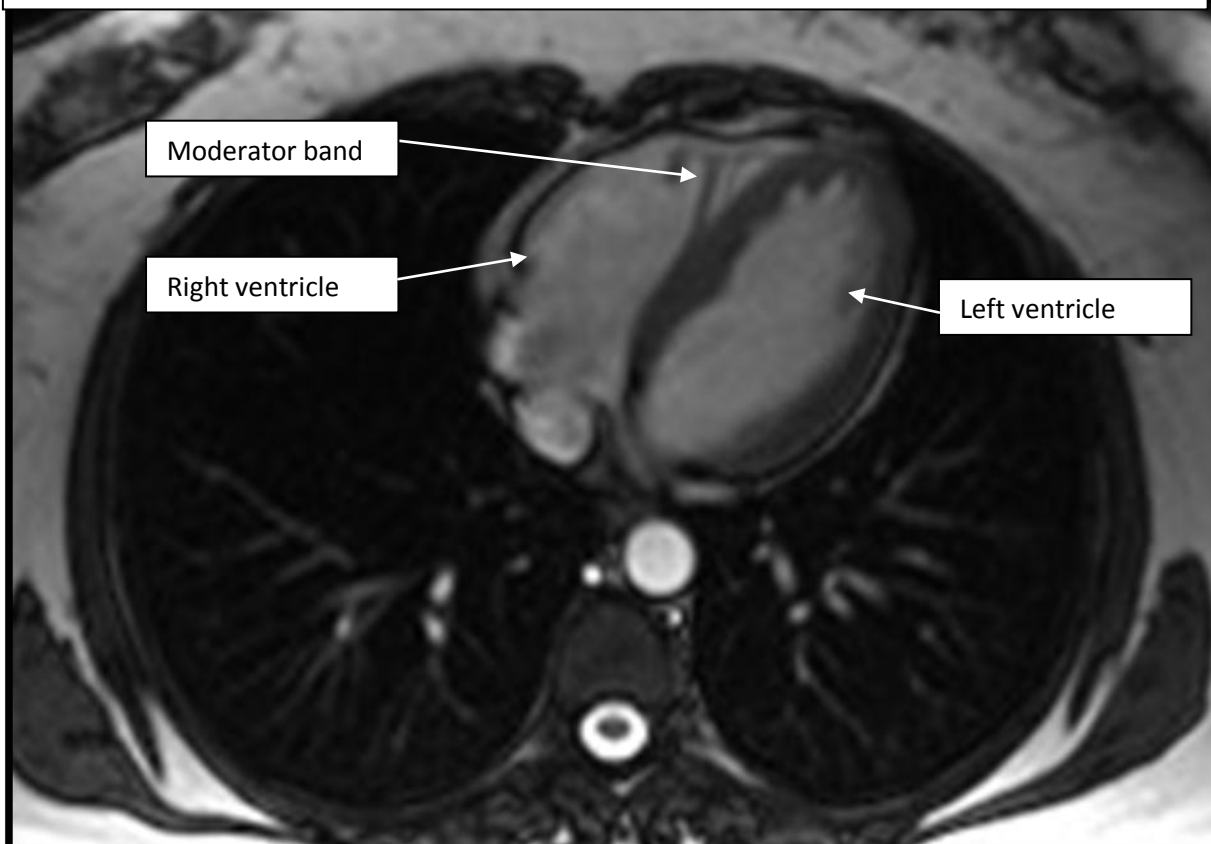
MRI TRUFISP axial sections of the chest at the level of heart chambers showing normal anatomy
